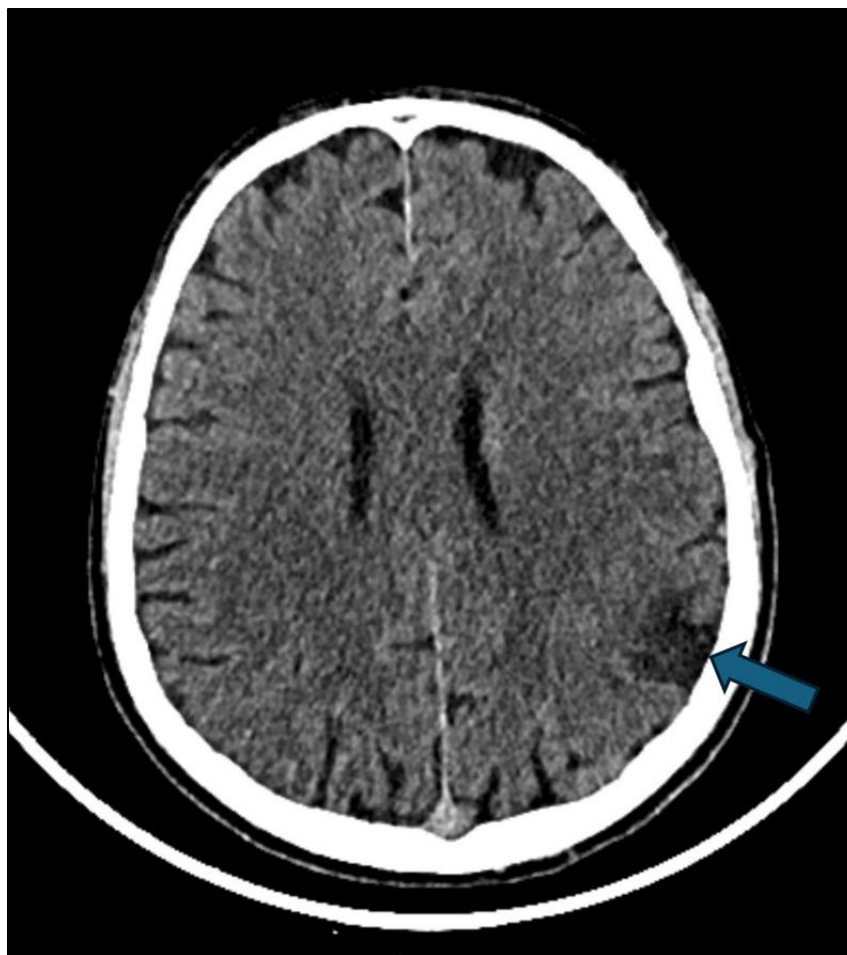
Non-contrast brain CT showing an area of hypodensity in the left frontal cortico-subcortical region (bleu arrow), within the territory of the left middle cerebral artery, consistent with a subacute ischemic infarction.
